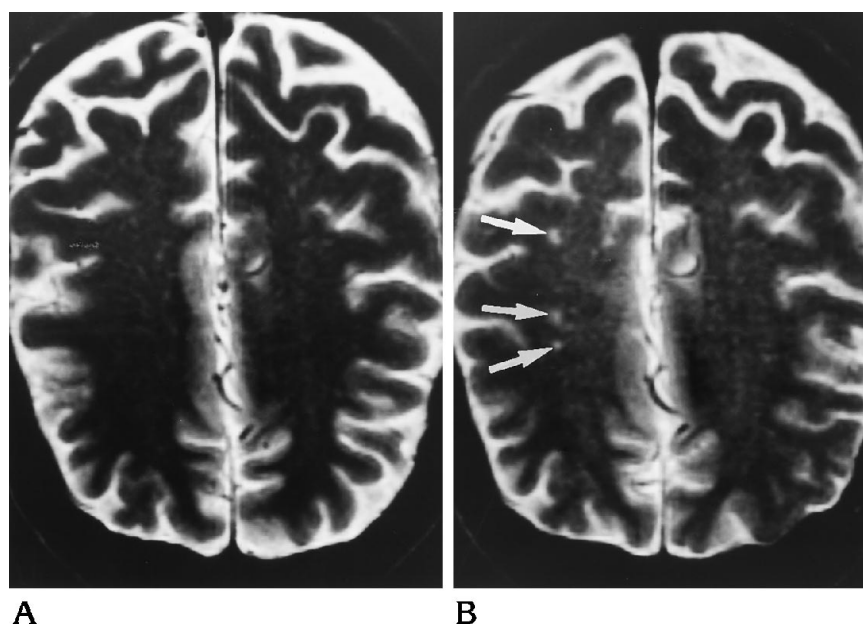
The preoperative T2-weighted MR image (A) in this 55-year-old man shows normal white matter in the centrum semiovale. The postoperative MR image (B), obtained 5 days after aortic valve replacement, shows three new lesions in the left centrum semiovale white matter (arrows). The patient experienced no new neurologic symptoms or signs after surgery.
